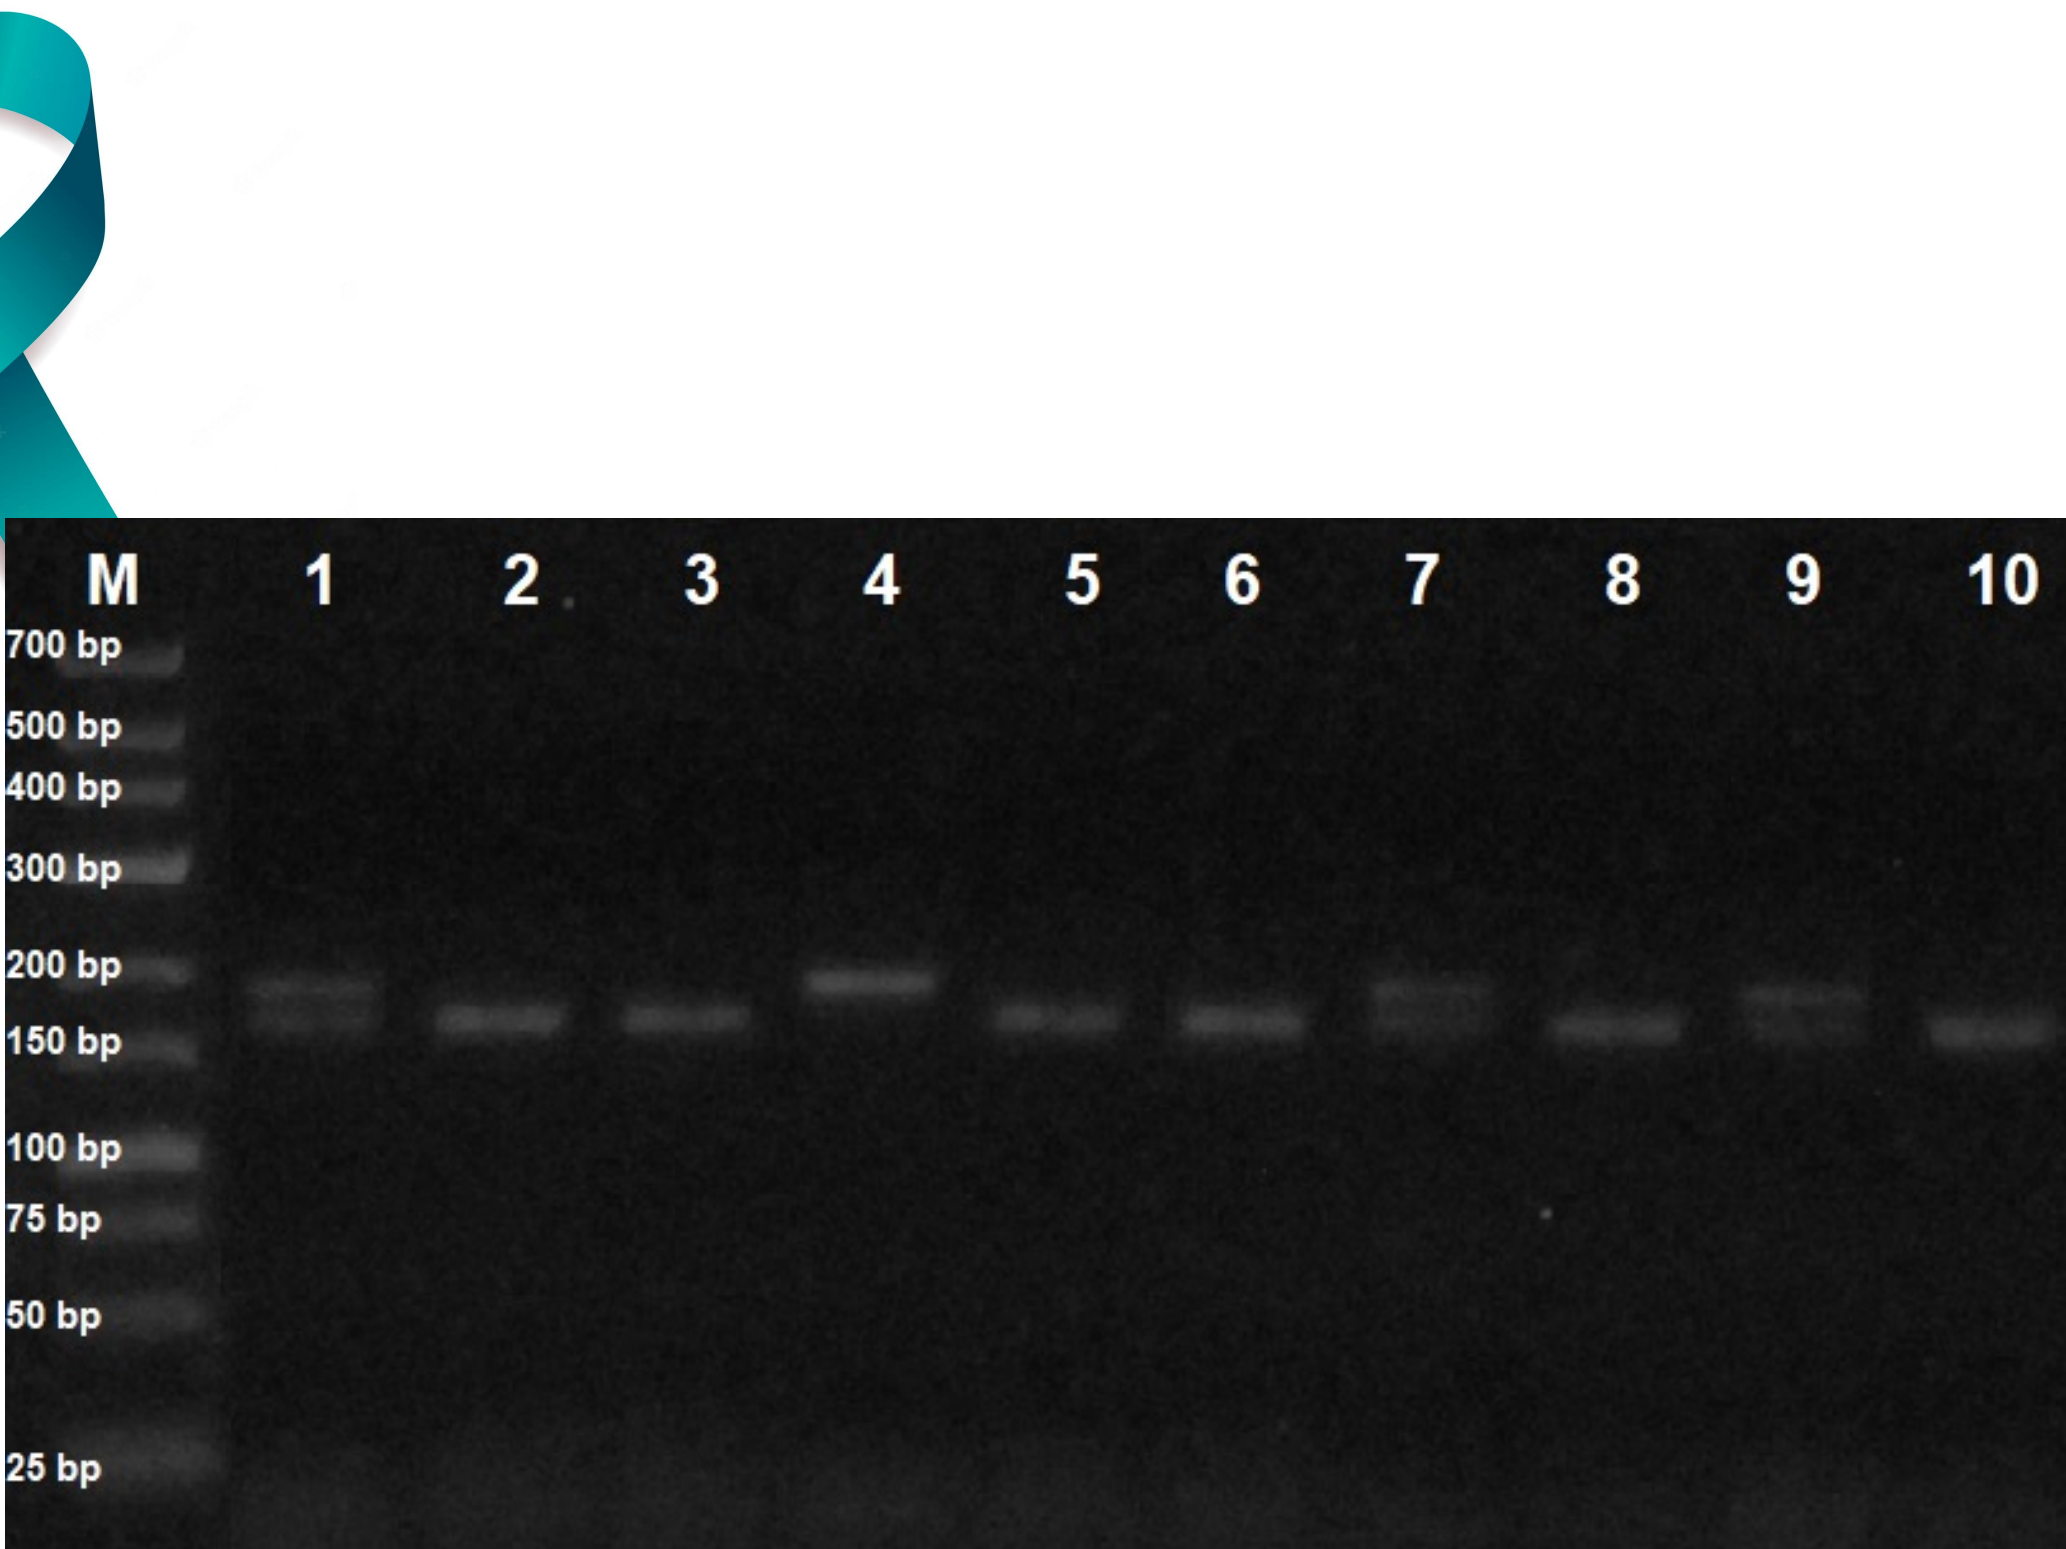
PCR-RFLP products of *TIRAP* rs8177374. From left to right. Lane M indicates DNA molecular marker GeneRuler Low Range DNA ladder (Thermo Fisher Scientific Baltics, Lithuania); CC genotype (141 and 20 bp fragments) are shown in lines 2, 3, 5, 6, 8 and 10; CT genotype (161, 141 and 20 bp fragments) – lines 1, 7 and 9; TT genotype (161 bp fragments) – line 4.
